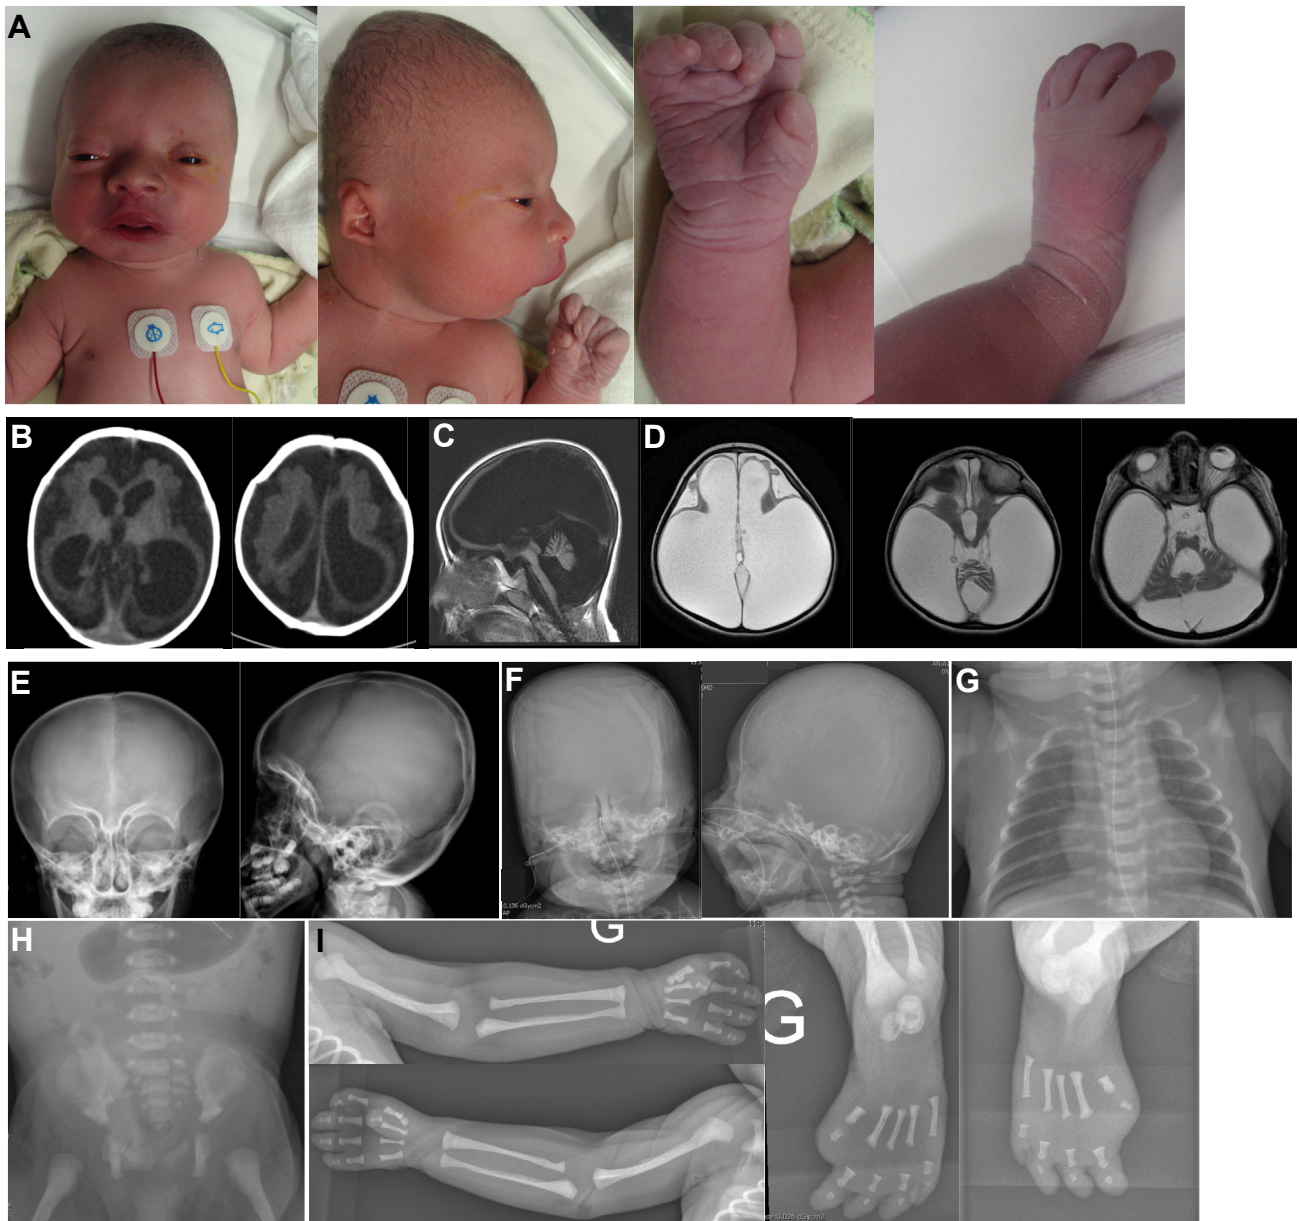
Photographs, brain imaging and X-rays of affected individuals. A. Individual 4. Note microcephaly, sparse scalp hair, absent eyebrows and eye lashes, protruding eyes, anteverted nares, short philtrum, micrognathia, low-set dysplastic ears with brachydactyly, thumb and hallux hypoplasia, and hypoplastic nails. B-D. Brain imaging of individual 3. B. CT axial: diffuse pachygyria with ventricular dilatation more significant at the left ventricle. C. MRI axial T2: frontal bilateral pachygyria, extreme bilateral ventricular dilatation, IV ventricle dilatation, thinned mesencephalus, atrophic cerebellum, and thinned thalamus. D. MRI sagittal T1: “J-shaped” sella, thinned cerebral cortical parenchyma and Dandy-Walker malformation. E and F. Skull X-ray, frontal and lateral plane of individuals from family 3 (E) and family 4 (F). Note unmineralized skull and craniofacial disproportion. G. Chest Radiograph showing narrow chest and hypoplastic clavicles in individual from family 4. H. Plain abdominal X-ray showing pelvic dysplasia in individual from family 4. I. Upper limb X-ray of individual 4 showing complete absence of thumb, hypoplasia of halluces, and hypoplastic middle and distal phalanges.
